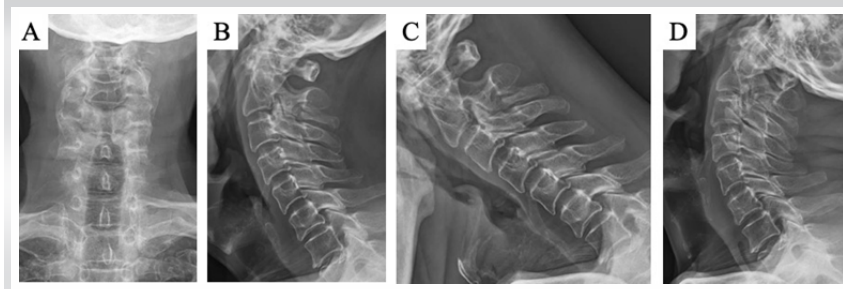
Pre-operative plain radiographs. (a) Anterior-posterior radiograph, (b) lateral radiograph, (c) lateral radiograph in flexion, and (d) lateral radiograph in extension.
